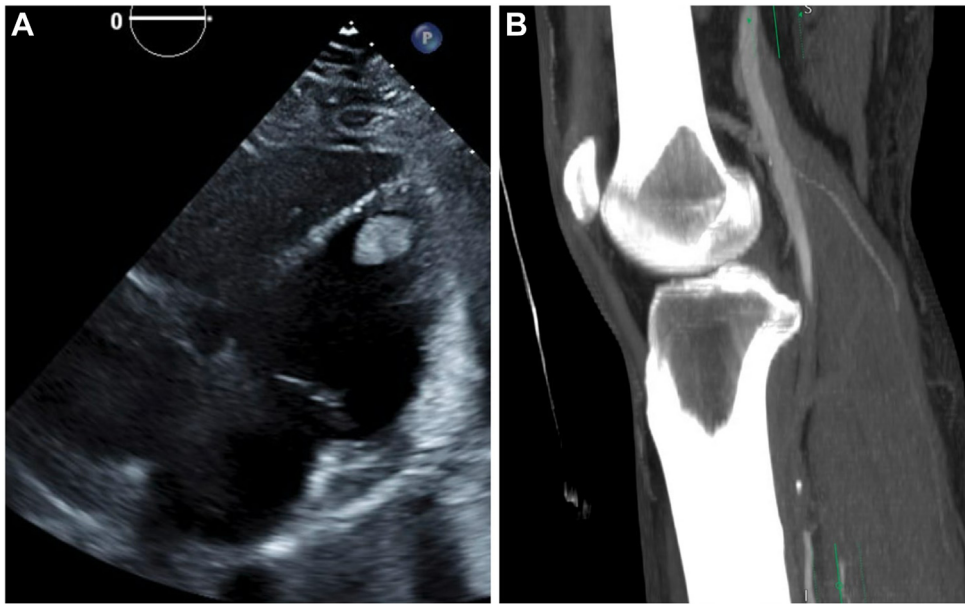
A: Transthoracic echocardiogram apical 4-chamber view demonstrating biventricular cavity dilation, biatrial enlargement, and a large, spherical, mobile thrombus measuring 2.4×1.6 cm seen adherent to the left ventricular apex. B: Multiplanar reconstruction of right lower extremity computed tomographic angiography demonstrated acute embolic occlusion of the distal right femoral artery.
